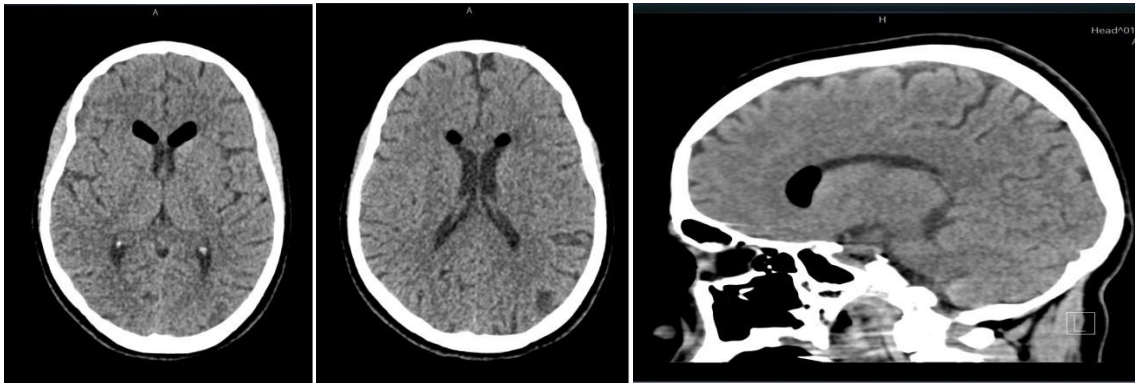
CT scan shows the presence of an air bubble in subarachnoid space
